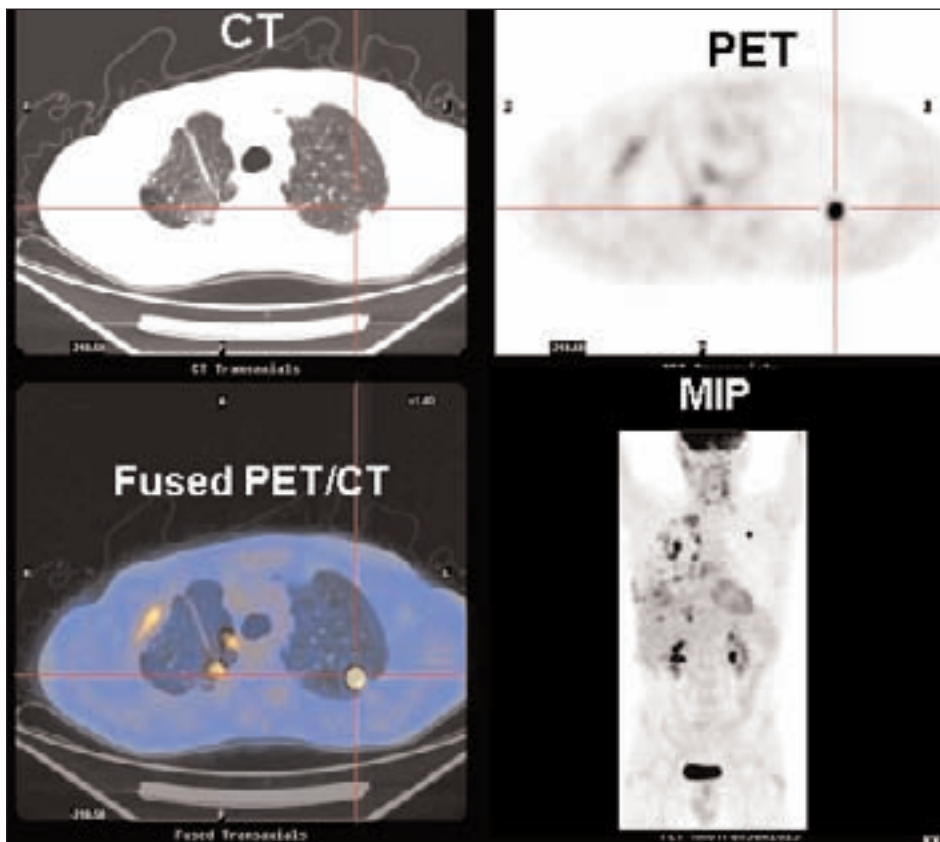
Clinical value of PET/CT information is apparent when a specific clinical question is addressed; in this example, staging of left upper lobe bronchogenic carcinoma (crosshairs on axial CT, PET, and fused images). Lack of left hilar or mediastinal activity (MIP image) suggests stage I disease. Widespread nodular activity in right pleural space is due to pleurodesis therapy. If the cancer had been located on the right lung, PET/CT scan would have been unhelpful for staging purposes.
